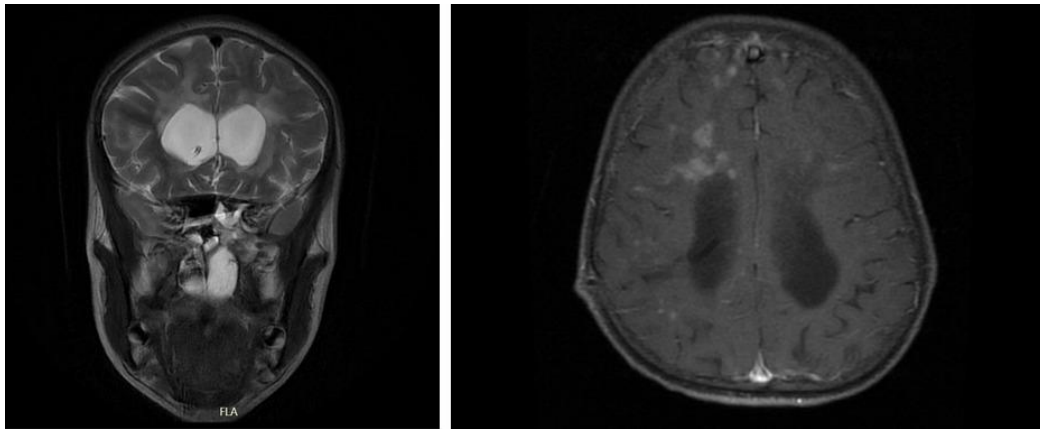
Left: Coronal T2-weighted image demonstrating bilateral symmetric ventriculomegaly and extensive periventricular white matter hyperintensity. Right: Axial post-contrast T1-weighted image showing patchy enhancement within the periventricular white matter lesions, indicating active demyelination.
